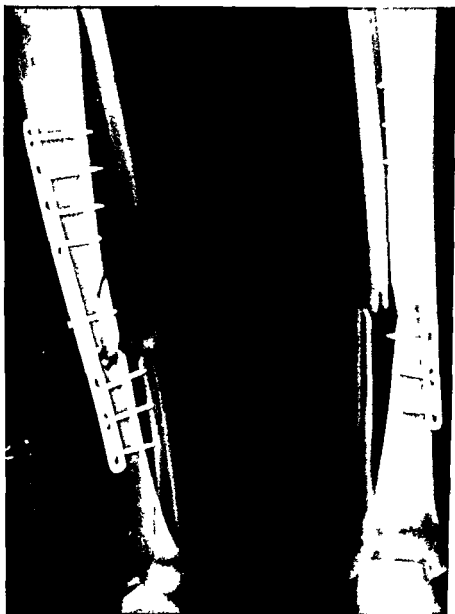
Radiograph of a plated tibial fracture. Nonunion followed. Again one cannot blame the implant metal. Perhaps a shorter plate would have maintained bone apposition adequately?
